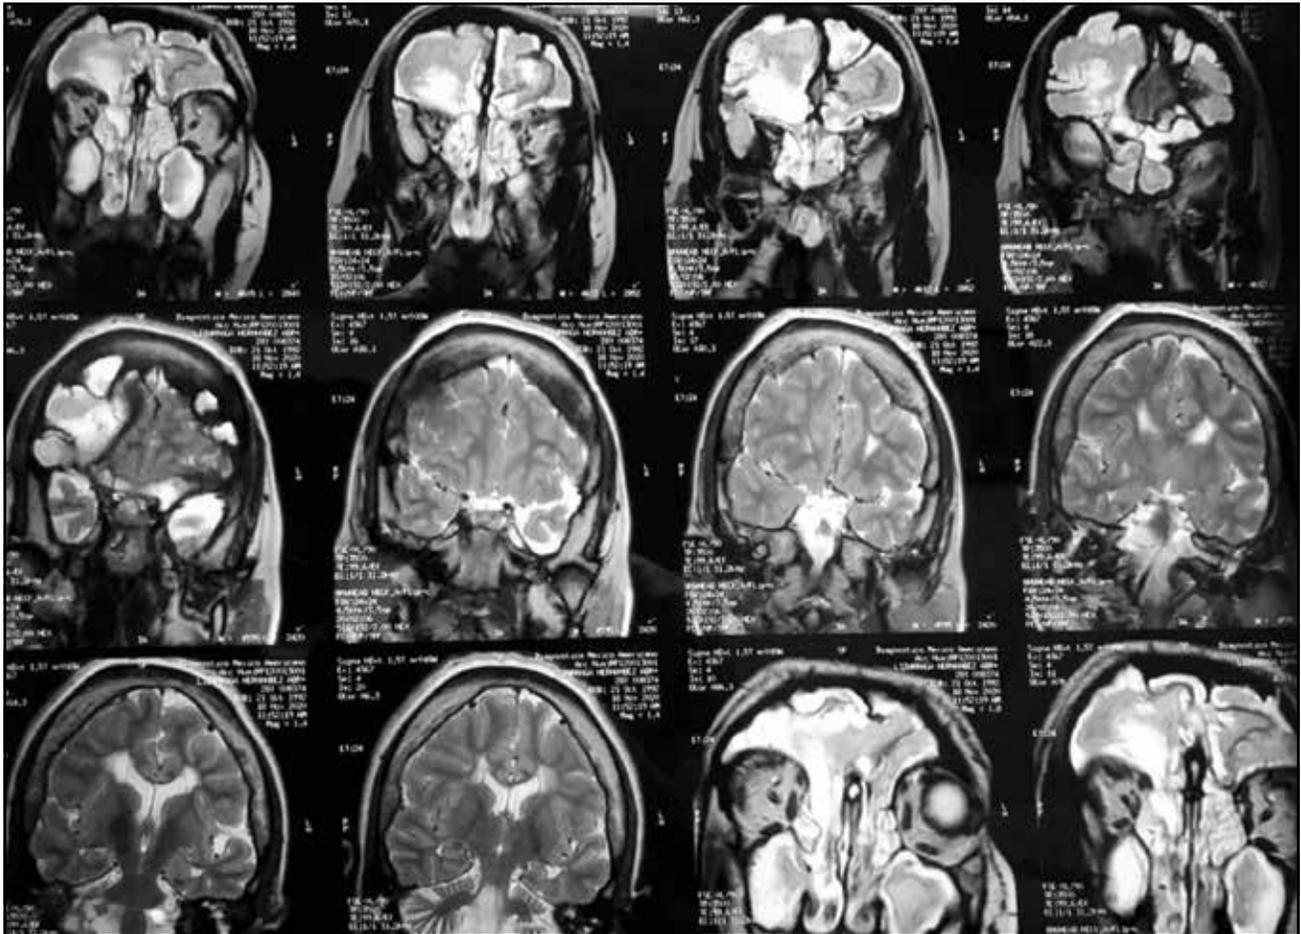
The nuclear magnetic resonance image in T2 sequence shows the absence of intracranial involvement.
